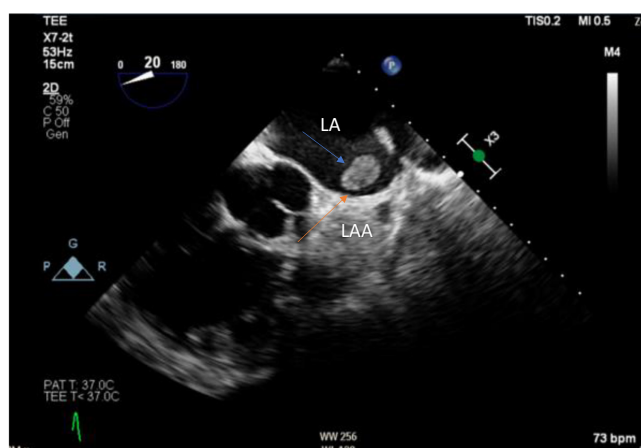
Figure 2: Transesophageal echocardiogram (TEE) showing large thrombus (blue arrow), sitting on top of the watchman device.
